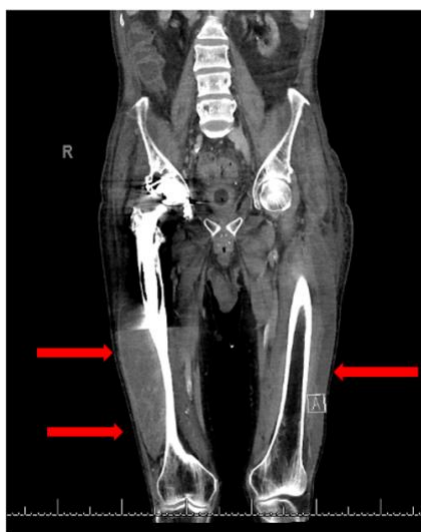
The magnetic resonance imaging (MRI) shows bilateral dense-content collections in the thighs (red arrows).
